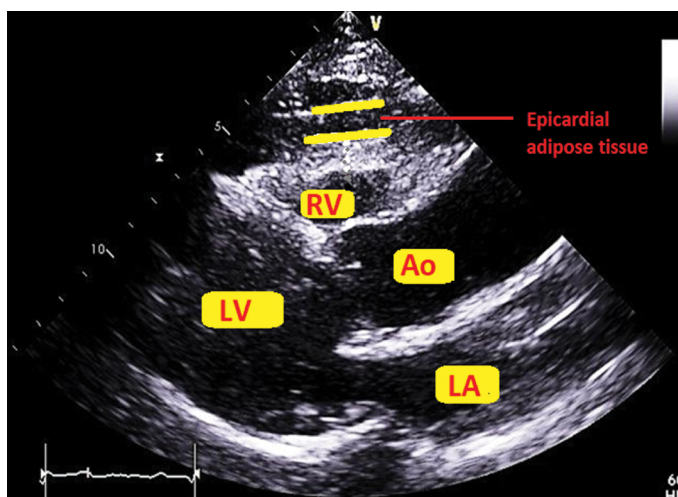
Epicardial adipose tissue in parasternal long-axis imaging.
